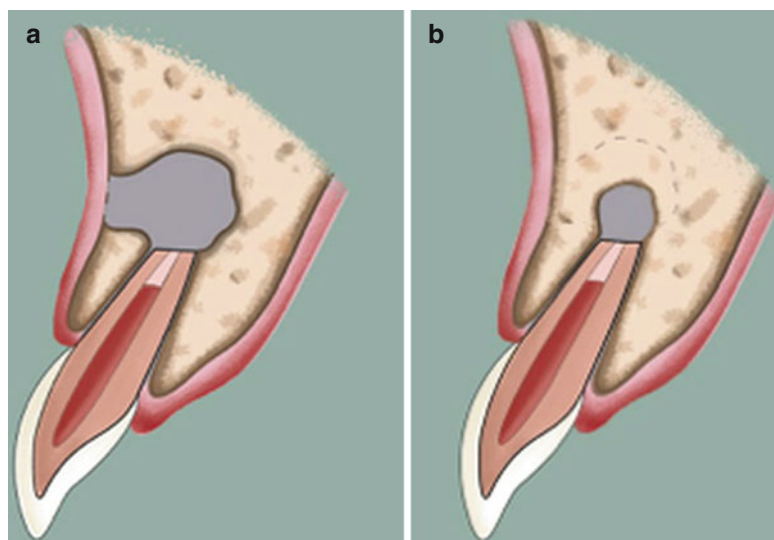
Incomplete healing (scar tissue). (a) Surgical bony defect after endodontic surgery. (b) Reduction in size of a periapical bony defect by bone formation from
